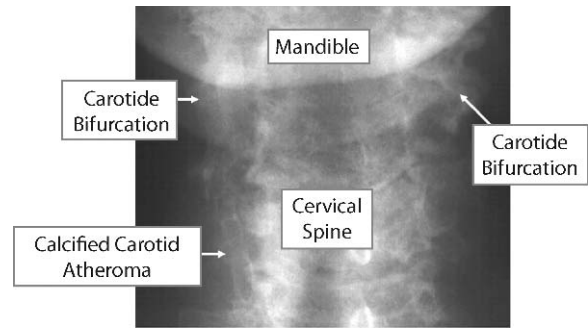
Anterior-posterior (AP) radiograph confirming bilateral deposits of calcified atheroma in the carotid bifurcation region and calcification along the whole length of the right common carotid artery. This radiograph excludes calcification being in a normal midline structure
